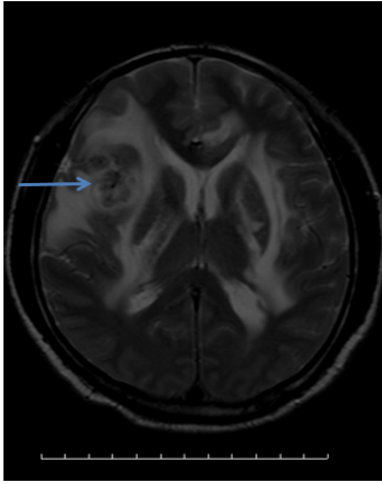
Right basal ganglia/radiographic crown occupying lesion (arrow).
